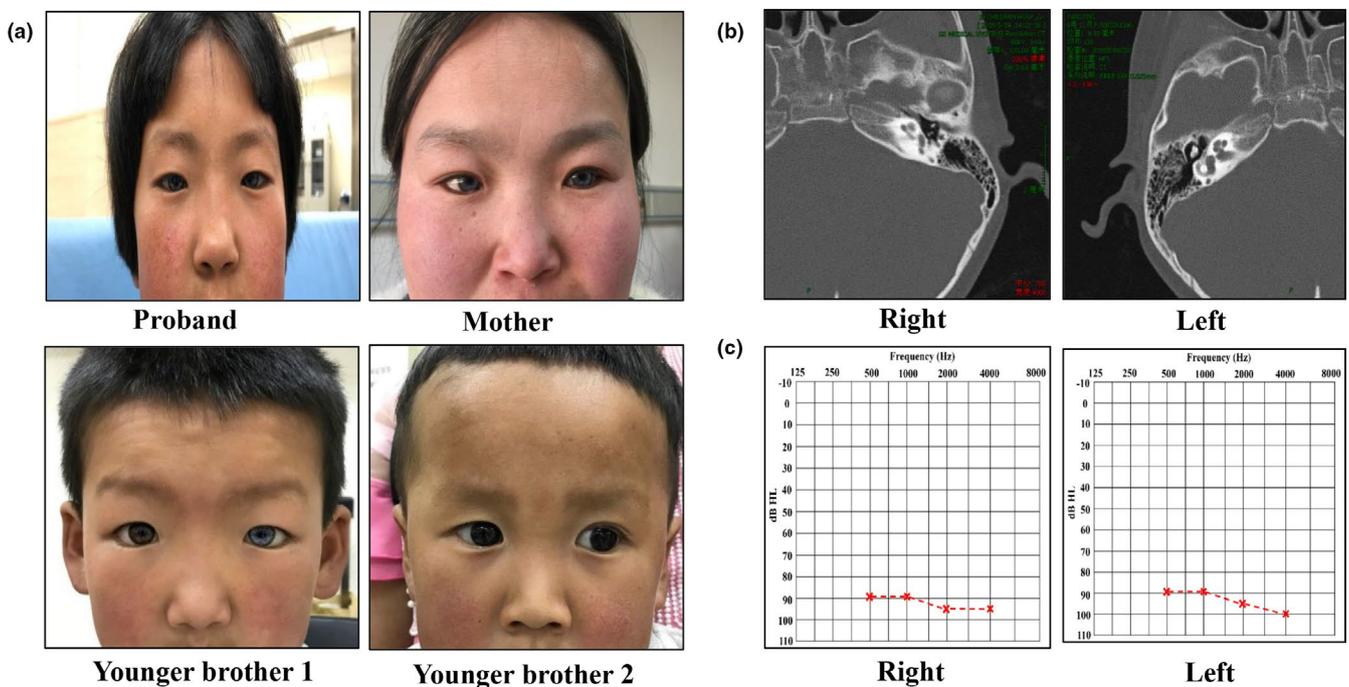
Clinical phenotypes in family diagnosed with WS I. (a) Iris heterochromia in the eyes, dystopia canthorum, and a pinch of white hair on forehead of the proband; Bright blue irides in eyes and unilateral severe hearing loss of the mother; Iris heterochromia in the left eye of one younger brother with normal hearing; Normal younger brother. (b) Temporal bone CT scan showed that the structure of the inner ear was normal. (c) Bilateral play audiometry (PA) detection. The x-axis indicates frequency in hertz (Hz) and the y-axis indicates hearing level in decibels (dB nHL)
